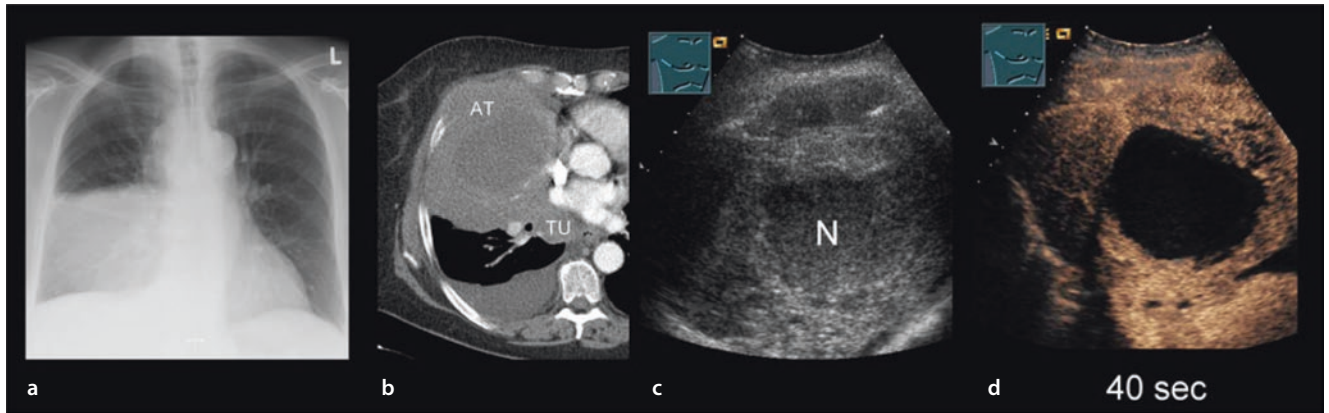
Man with bronchial carcinoma. a The chest X-ray reveals shadowing in the lower field of the right lung. b CT shows a central tumor formation (TU) with downstream atelectasis (AT). c B-mode ultrasound reveals a clearly inhomogeneous space-occupying lesion
